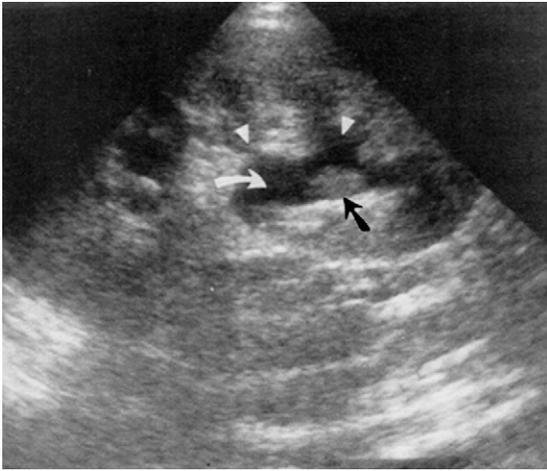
Hydronephrosis due to a *Candida* fungus ball. Longitudinal sonogram of the right kidney shows dilated calyces (arrowheads) joining a dilated renal pelvis (curved arrow). There is an echogenic (dense) focus (arrow) which represents the fungus ball made of fungal elements and necrotic debris. (Reproduced with permission from Kay²¹¹).
